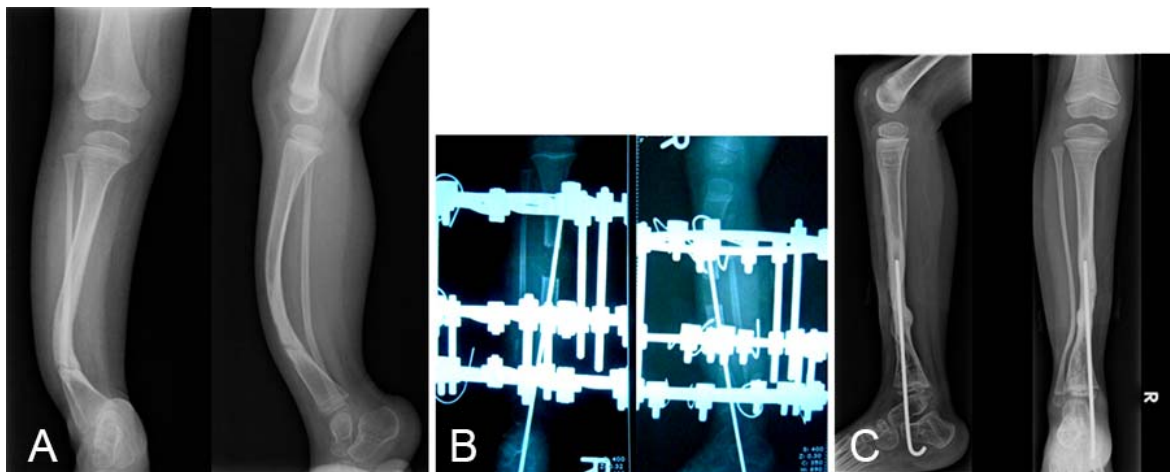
(A) Preoperative radiograph of a 4-year-old girl with pseudarthrosis right tibia, (B) Postoperative radiograph showing combined Ilizarov and intramedullary nailing using titanium elastic nail (approximately 4 cm of bone lengthening was achieved), (C) AP and lateral radiographic at 2-year follow-up showed healing of pseudarthrosis with good AP and Lateral alignment.
